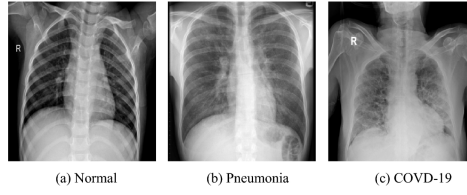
Normal Vs Pneumonia and Covid 19 X-ray Images
